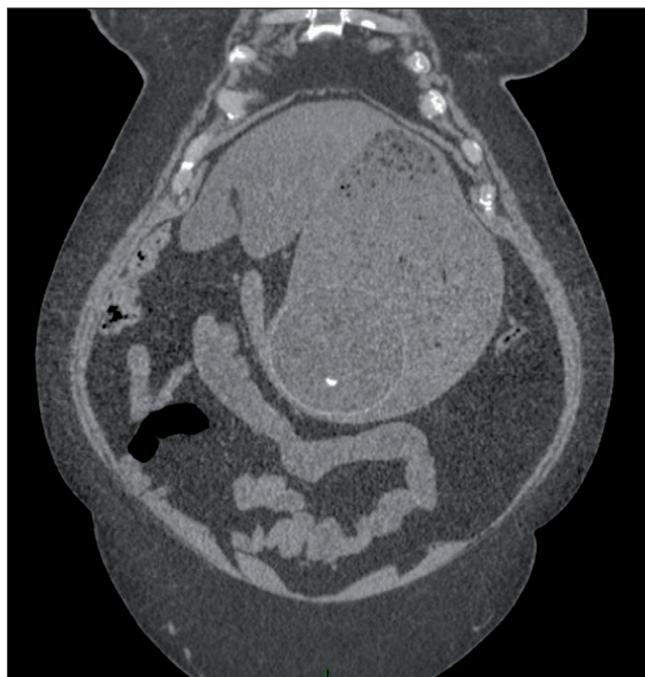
Coronal reconstruction of CT, showing the impacted balloon occluding the pylorus and causing gastric outlet obstruction despite the nasogastric tube.
